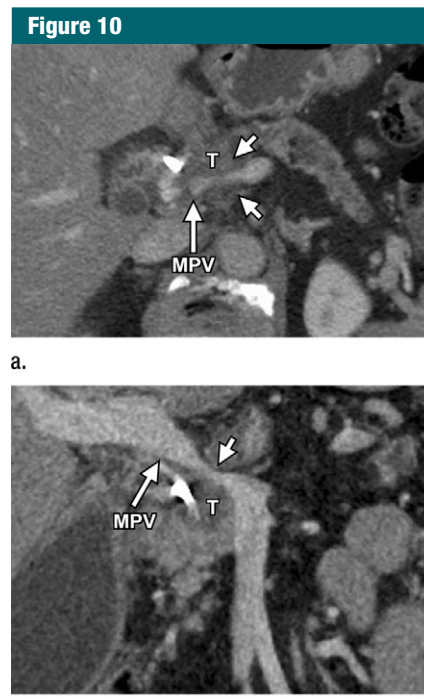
Images in a 76-year-old man with tumor with more than 180° contact with the main portal vein (MPV). (a) Axial contrast-enhanced biphasic multidetector CT angiogram demonstrates a pancreatic head mass (*T*) with tumor contact extending more than 180° around the MPV (short arrows). (b) The focal vessel narrowing and length of contact is better delineated on the coronal view (short arrow). Despite the degree of tumor contact with the MPV, the presence of suitable vessel proximal and distal to the narrowing potentially allows for safe resection and venous replacement, which places the patient in the borderline resectable category.
